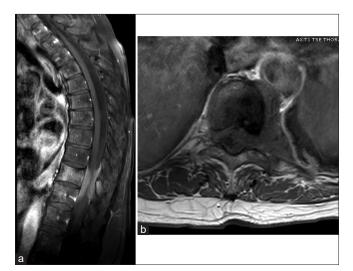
(a) Sagittal T1-weighted magnetic resonance imaging (MRI) with contrast demonstrating a homogeneously enhancing lesion in the T10 vertebral body with ventral and dorsal epidural extension causing severe spinal cord compression. (b) Axial T1-weighted MRI with contrast demonstrating a predominantly left-eccentric epidural lesion causing rightward displacement of the spinal cord. Of note the left T10 nerve root appears completely enveloped in the tumor.
